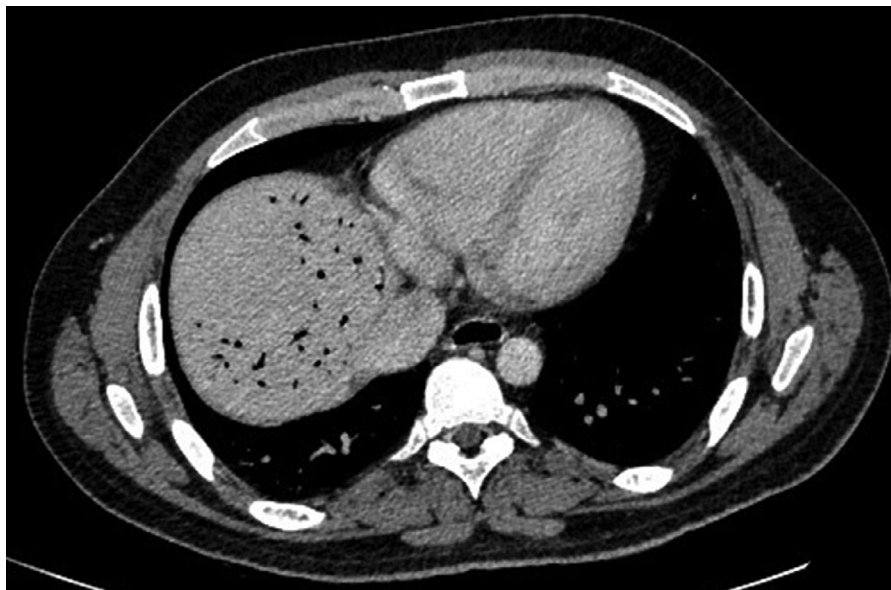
Computed tomography image showing the hepatic portal venous gas with its characteristic peripheral distribution.
